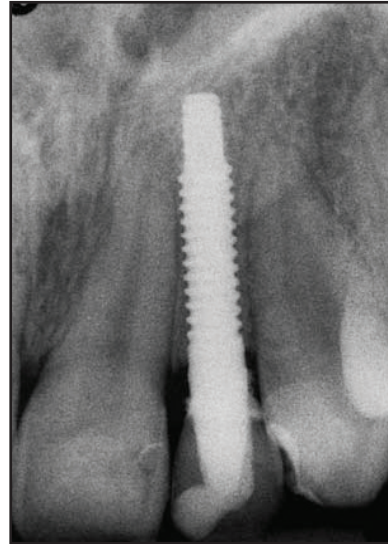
Radiographic appearance at 6 months postoperatively.
